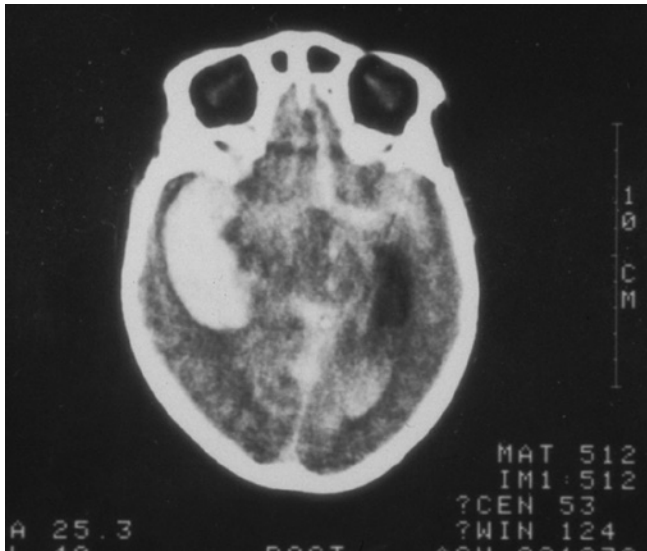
Computed tomography scan of the brain demonstrating a cerebrovascular accident (stroke) lesion that extended from the midbrain to the temporal lobe.
